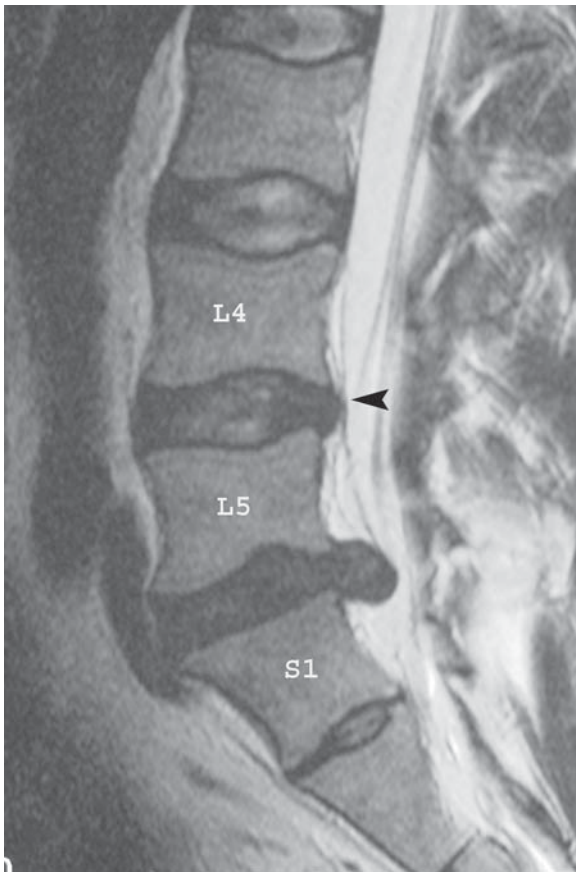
Sagittal T2 MRI of a large disc herniation at L5–S1. Also notice the disc bulge at L4–L5 (*arrowhead*).
